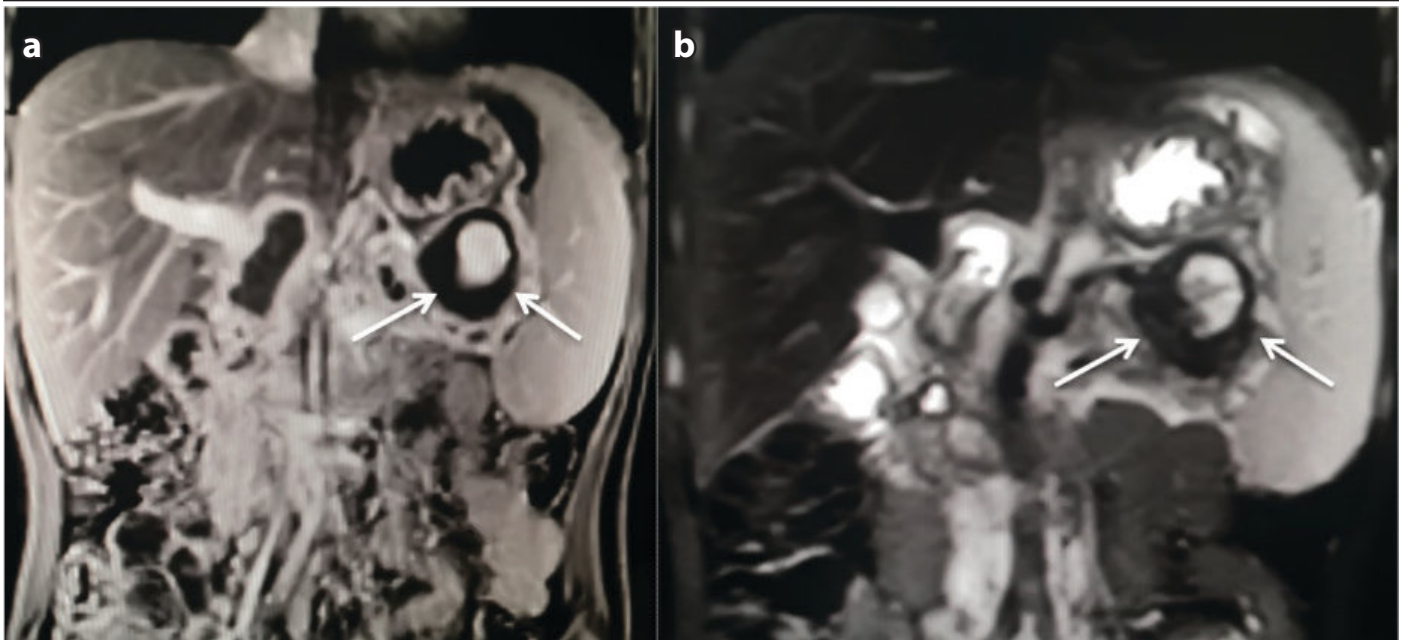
Coronal T2 weighted (a) and contrast enhanced MRI (b) shows pseudoaneurysm arising from the distal segment of splenic artery (white arrows).
